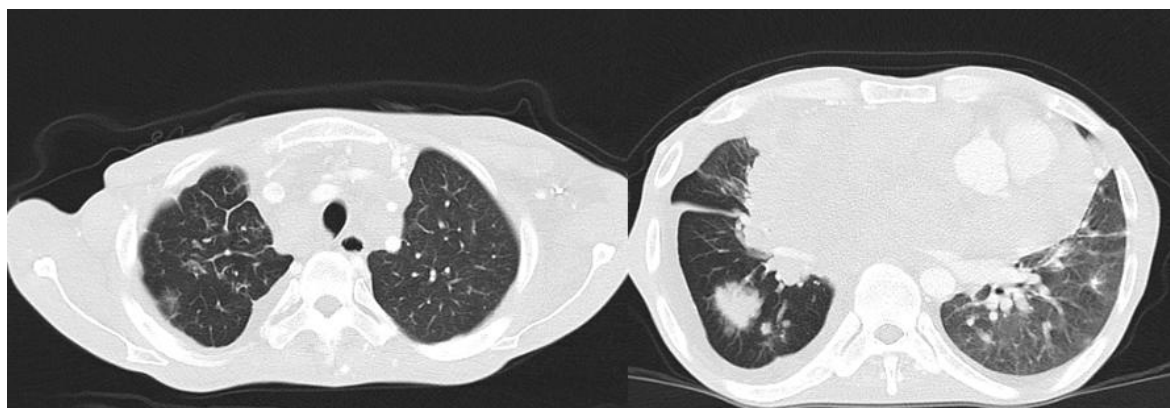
Parenchymal window of chest CT scan of a patient with mediastinal NEC, showing septal thickening and right lower lobe mass
